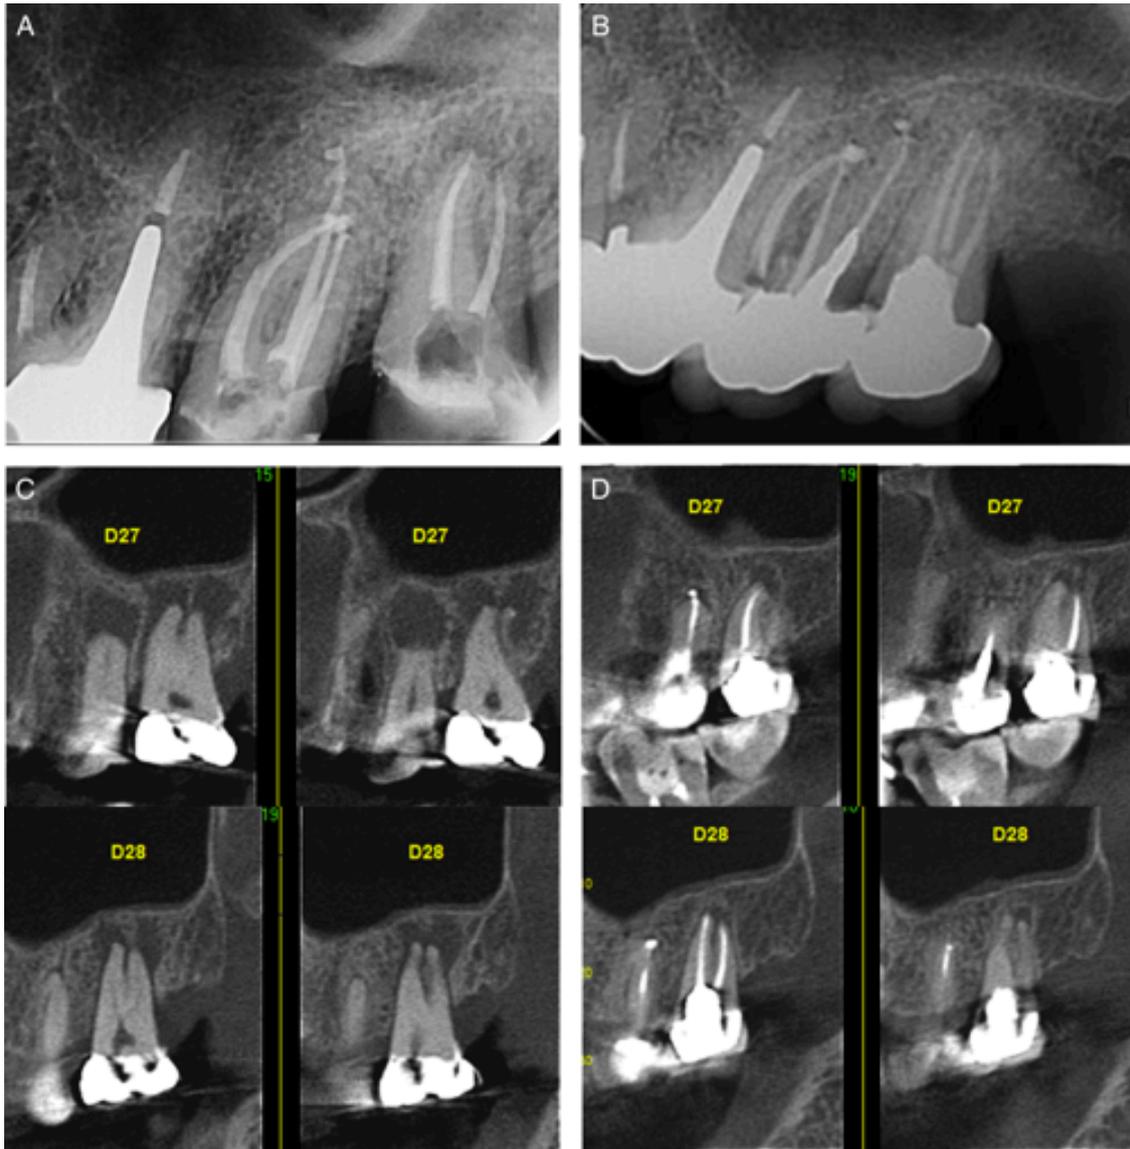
A: control x-ray at 3 months. B: control x-ray at 1 years. C: Preoperative CBCT scan. D: CBCT scan at 1 year (21).
